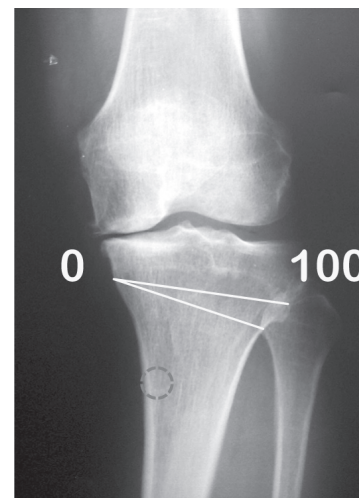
Preoperative X-ray image at anteroposterior plane showing deformity in varus at the anatomical axis.
